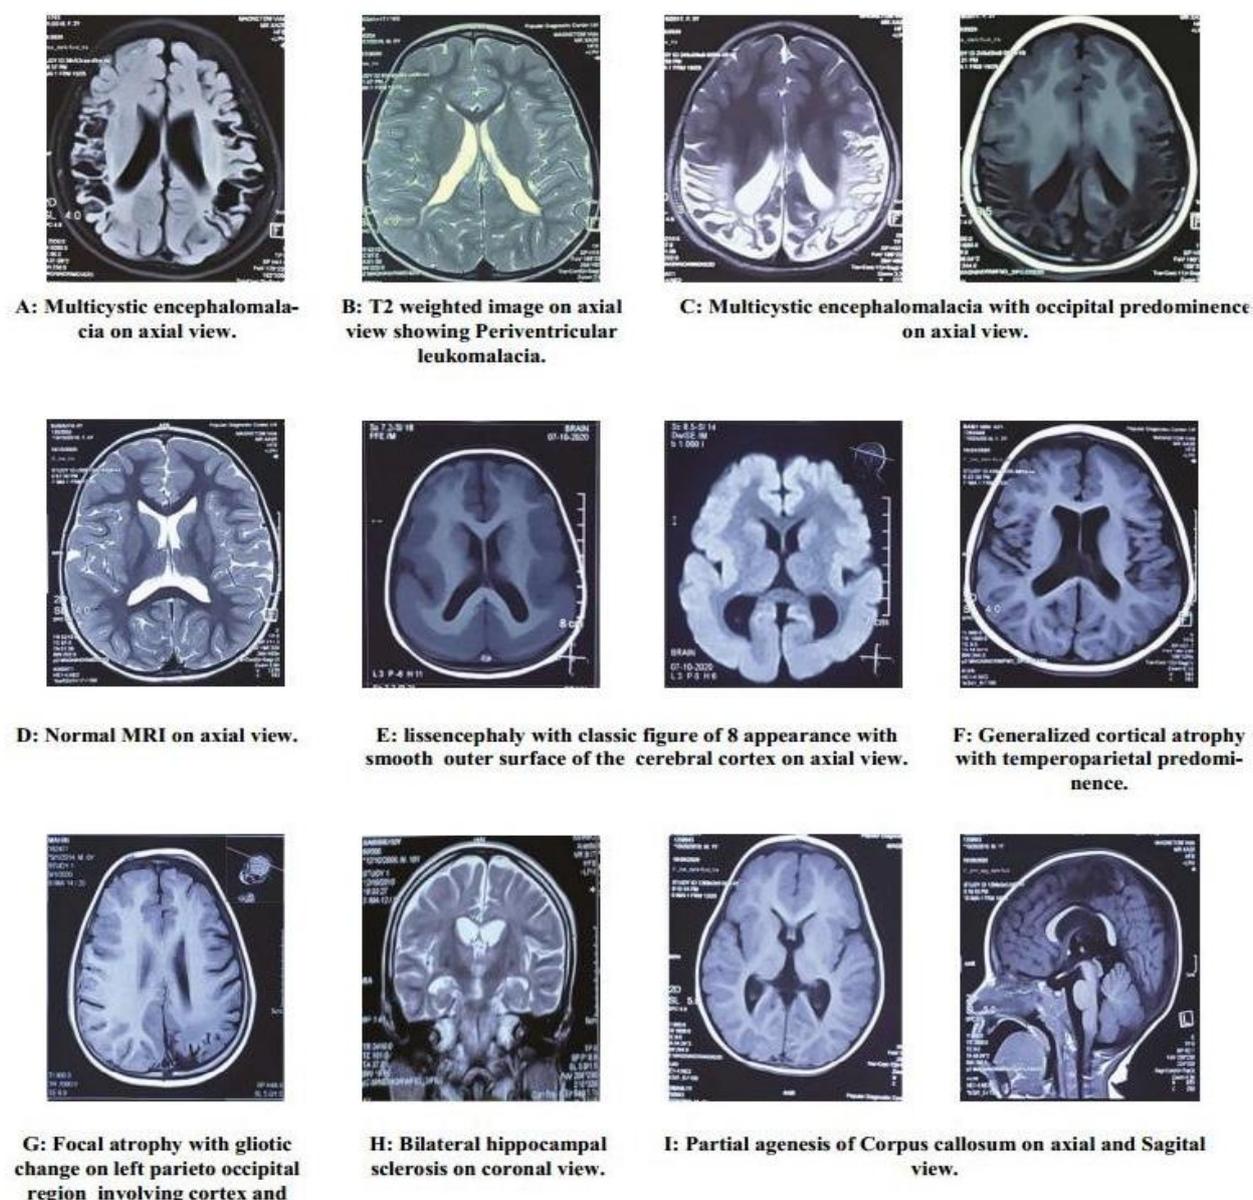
Different magnetic resonance imaging pictures of study cases
